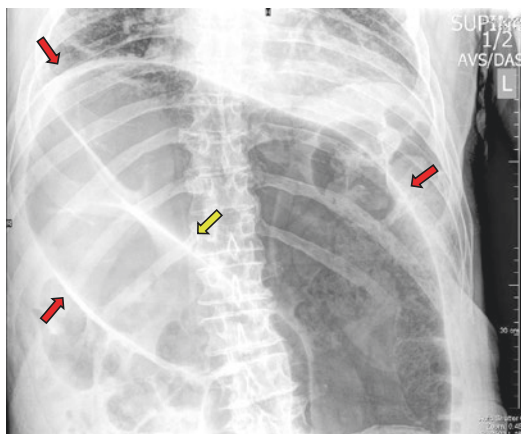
65-year-old man with a sigmoid volvulus. Supine anteroposterior radiograph of the abdomen demonstrates the classic “coffee bean” sign (red arrows) in sigmoid volvulus. The apex of the volvulus points toward the right upper quadrant. Note also the central cleft (yellow arrow) of the coffee bean
